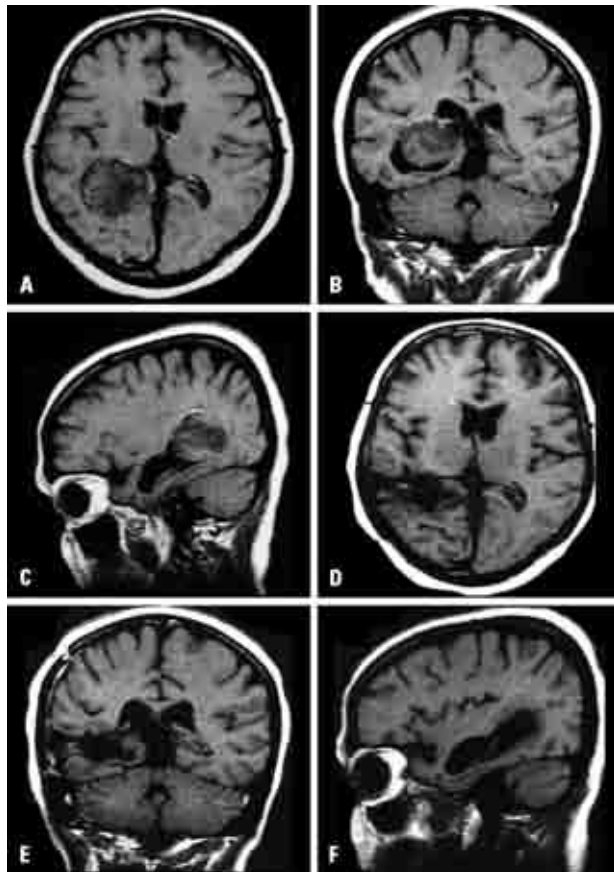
Case 3. A 52-year-old woman with a history of persistent and progressive headache after a cycle fall. [A, B and C] Pre-operative MRI. [D, E and F] Post-operative MRI after 6 months.
